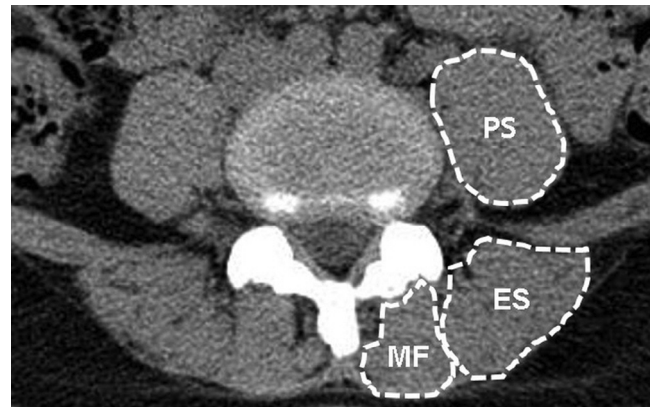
Boundaries of multifidus, erector spinae, and psoas muscles on abdominopelvic computed tomography at the L4–L5 disc level.
